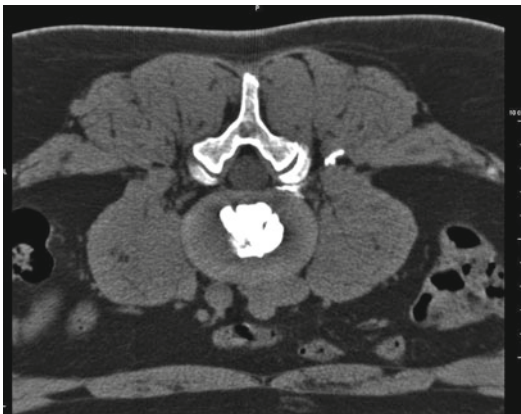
Normal finding as obtained by CT-guided discography
